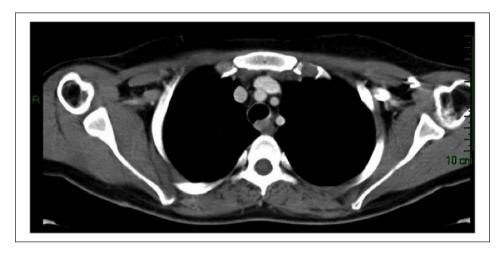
Chest CT image of the mass lesion that was obliterating tracheal lumen.
